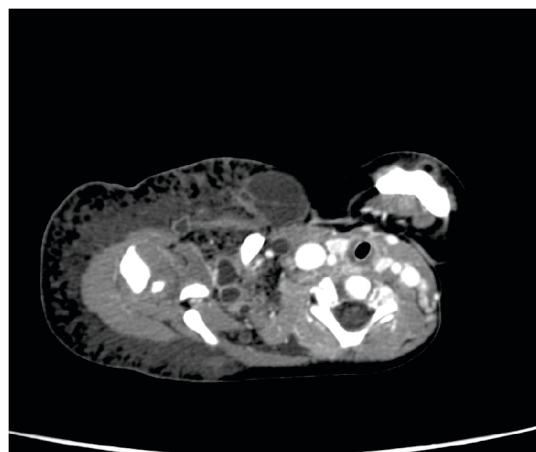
CT Angiography, axial image showing multiple small and large well-defined cystic areas in the right upper limb as well as along the chest wall representing dilated lymphatic spaces, lymphoceles.
